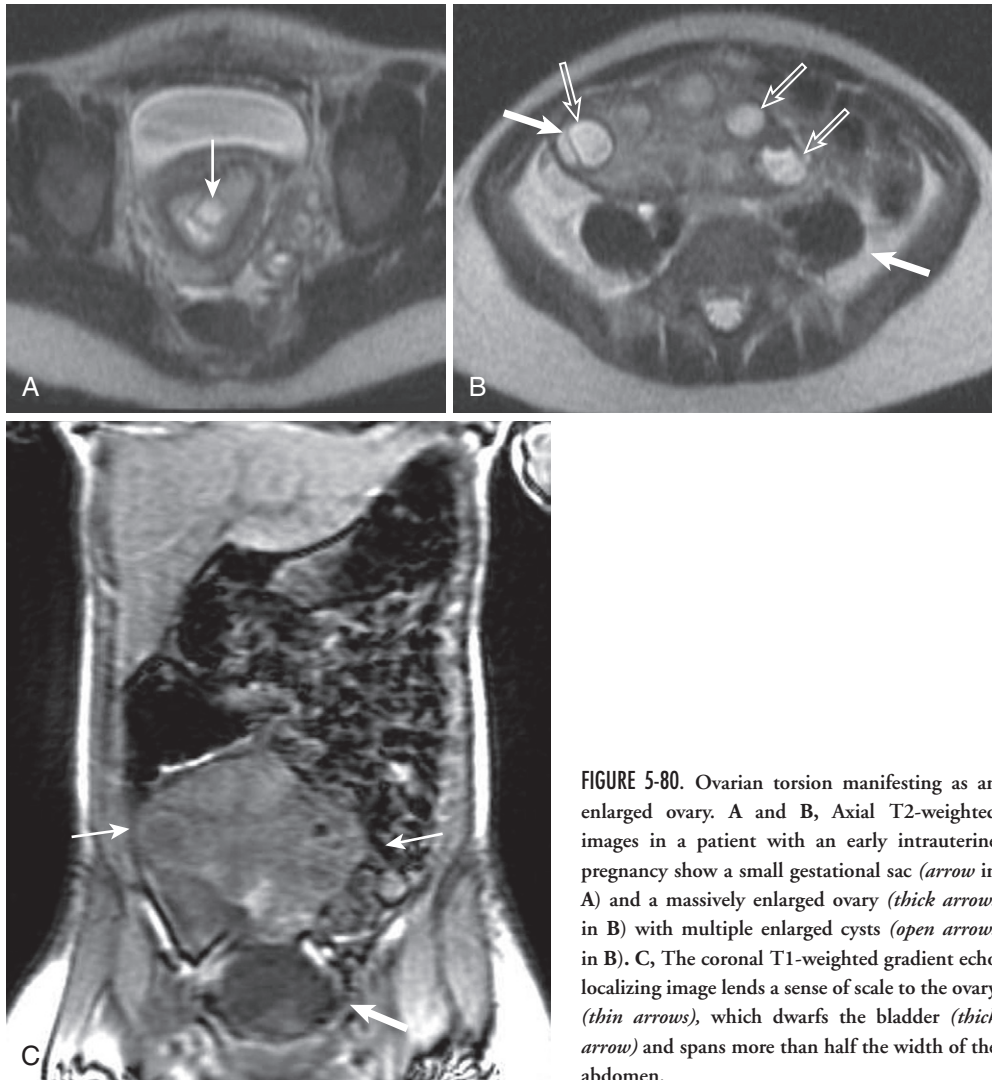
Ovarian torsion manifesting as an enlarged ovary. A and B, Axial T2-weighted images in a patient with an early intrauterine pregnancy show a small gestational sac (*arrow* in A) and a massively enlarged ovary (*thick arrows* in B) with multiple enlarged cysts (*open arrows* in B). C, The coronal T1-weighted gradient echo localizing image lends a sense of scale to the ovary (*thin arrows*), which dwarfs the bladder (*thick arrow*) and spans more than half the width of the abdomen.
